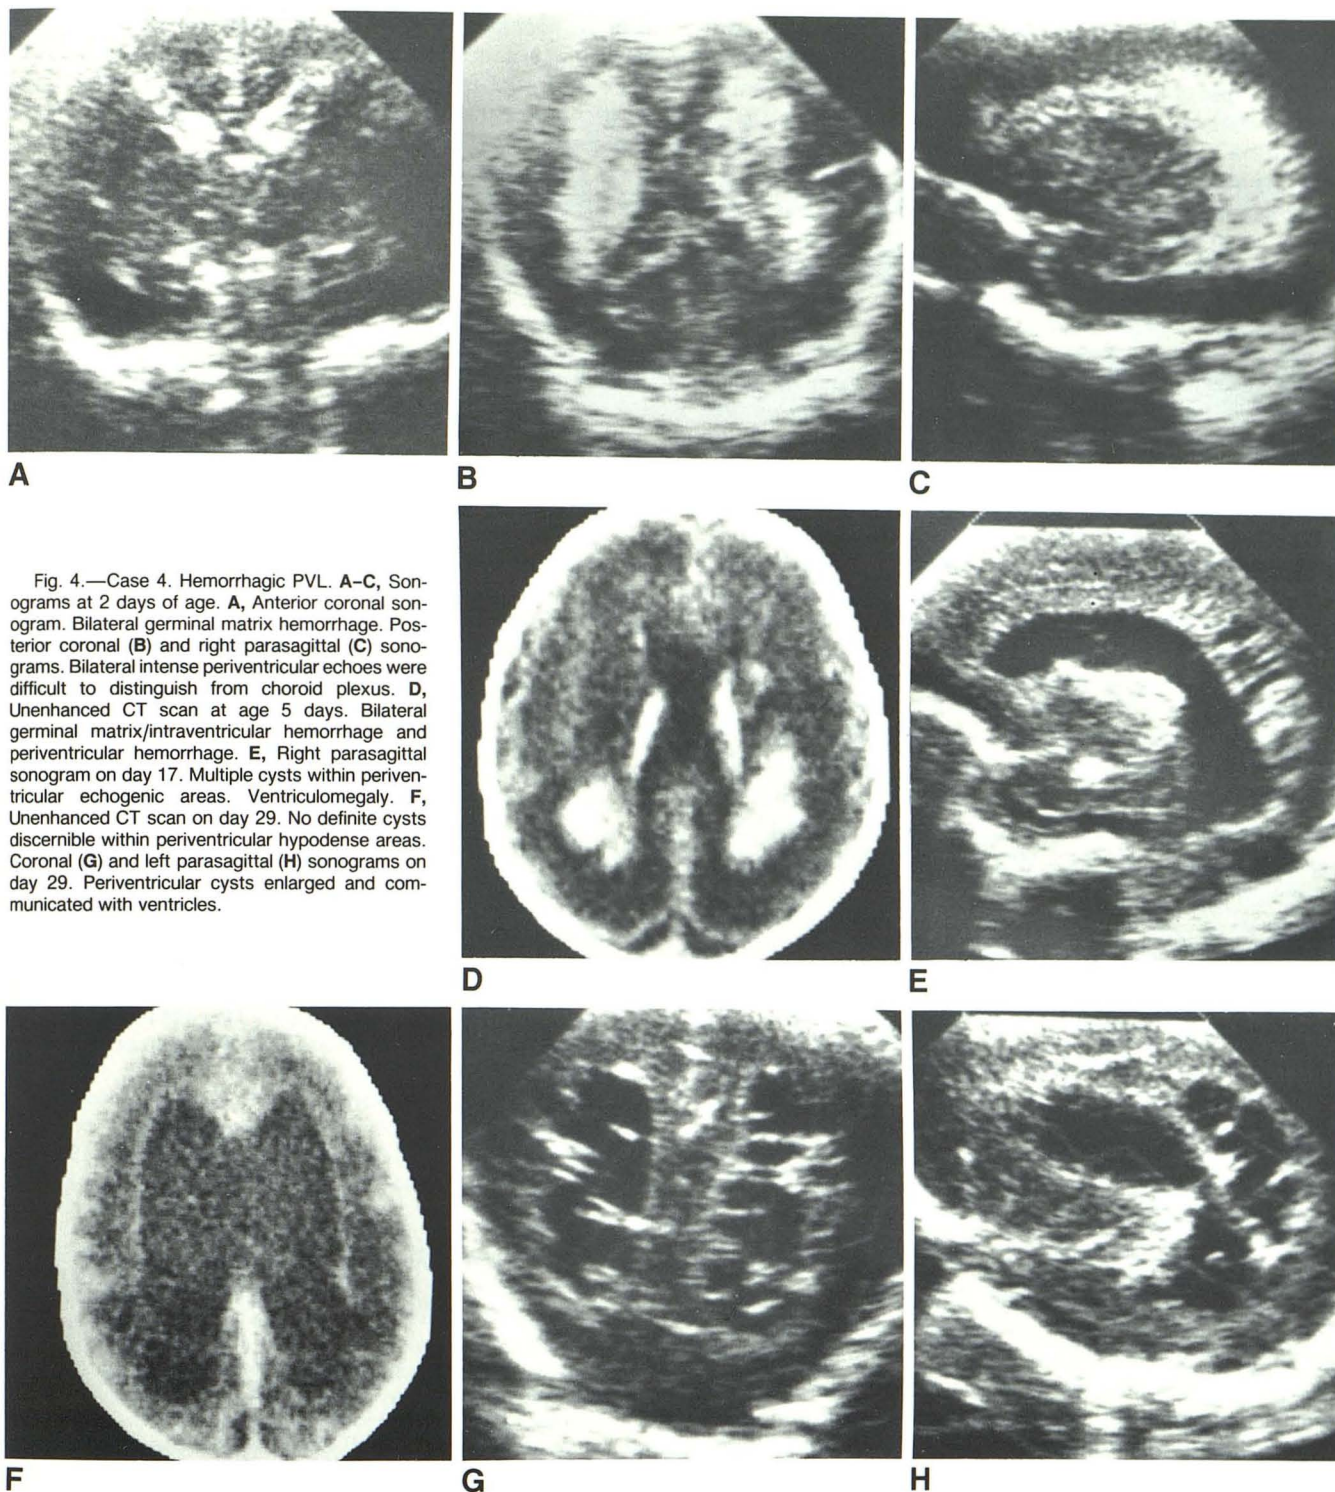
Case 4. Hemorrhagic PVL. A–C, Sonograms at 2 days of age. A, Anterior coronal sonogram. Bilateral germinal matrix hemorrhage. Posterior coronal (B) and right parasagittal (C) sonograms. Bilateral intense periventricular echoes were difficult to distinguish from choroid plexus. D, Unenhanced CT scan at age 5 days. Bilateral germinal matrix/intraventricular hemorrhage and periventricular hemorrhage. E, Right parasagittal sonogram on day 17. Multiple cysts within periventricular echogenic areas. Ventriculomegaly. F, Unenhanced CT scan on day 29. No definite cysts discernible within periventricular hypodense areas. Coronal (G) and left parasagittal (H) sonograms on day 29. Periventricular cysts enlarged and communicated with ventricles.
